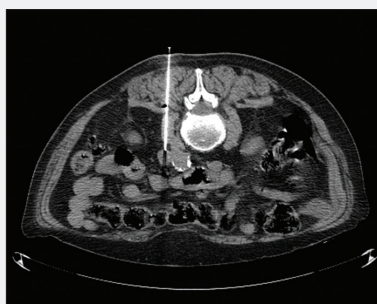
CT-guided biopsy of the 1.2-cm para-aortic lymph node.
